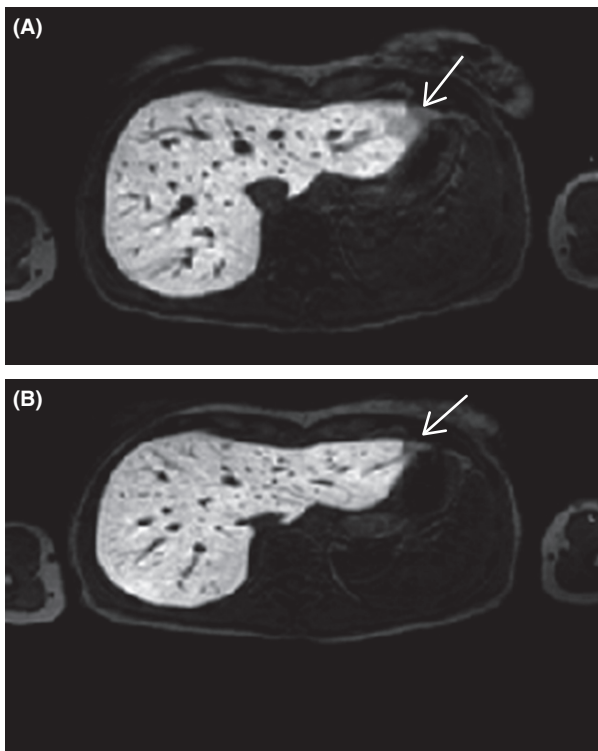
(A) Axial T1-weighted Primovist MRI in the delayed hepatobiliary phase with low signal lesion corresponding to lesion on CT. (B) Axial T1-weighted Primovist MRI in the delayed hepatobiliary phase with partial resolution of lesion at 5 months.
